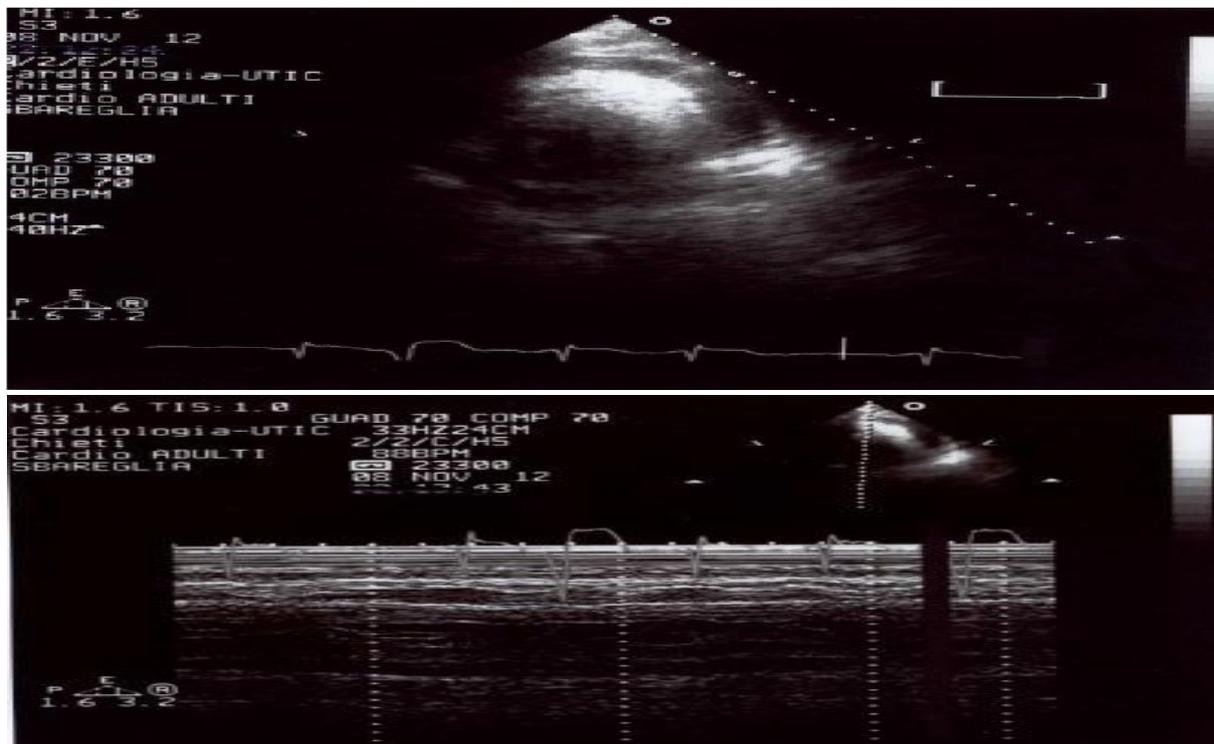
Cardiac tamponade: Echocardiographic findings (our personal case).
